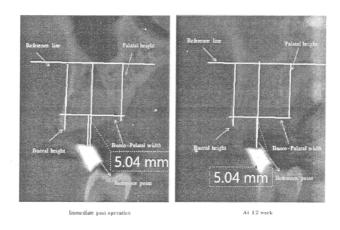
Dimension measurement in Cone beam CT
